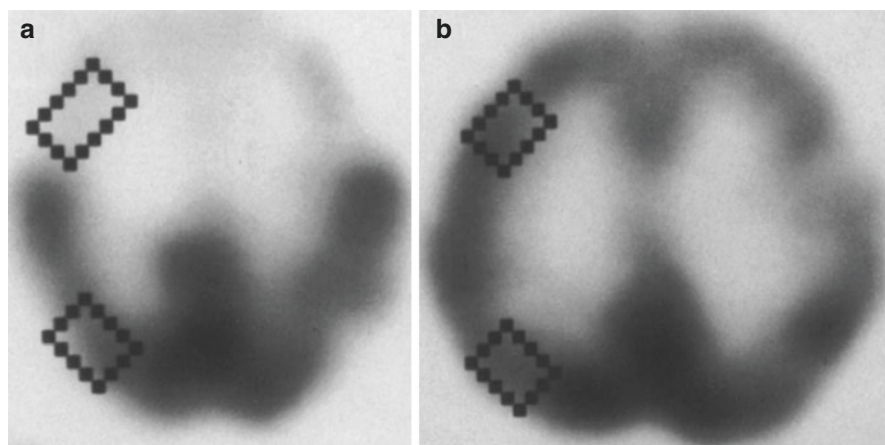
^{123}I -IMP SPECT in an ALS patient with dementia (a) compared to a healthy control (b). There is a clear loss of frontotemporal uptake in keeping with the understanding of extra-motor spread of pathology (Adapted from Sawada et al. (1988) with kind permission of Springer Science+Business Media; superimposed boxes show quantitative sampling regions)
